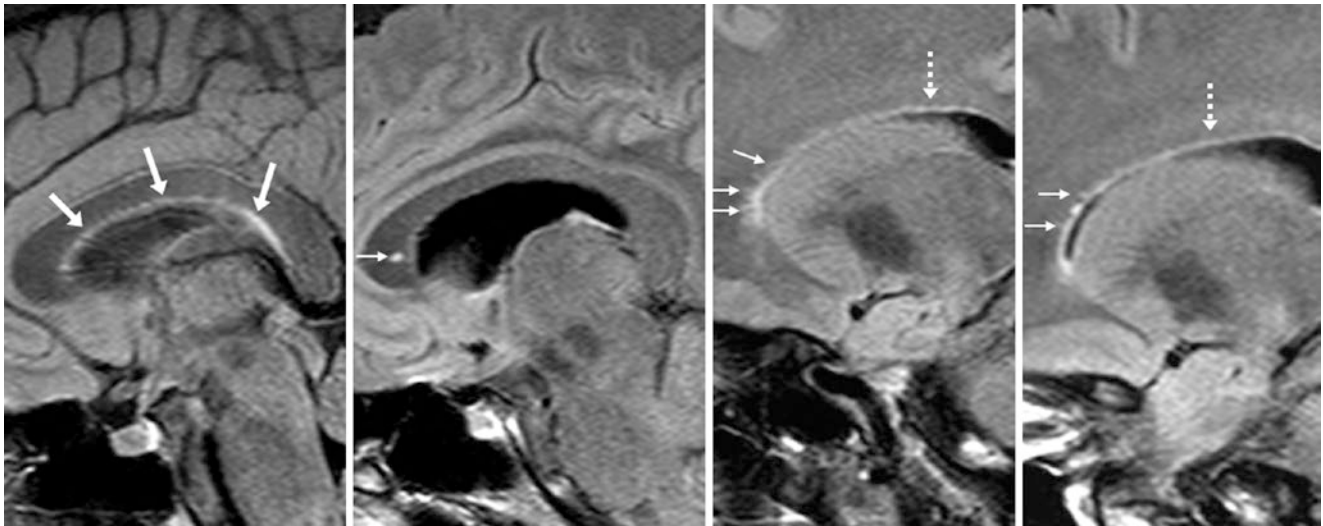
Comparison case of a patient with early multiple sclerosis (MS). An 18 year old had normal bright signal at the callosal-septal interface (*arrows*) oriented parallel to the lateral ventricles on a sagittal FLAIR midline image (*left*). Just left of the midline (*left middle*), there was an MS lesion (*tiny arrow*) within the callosal genu. More laterally
